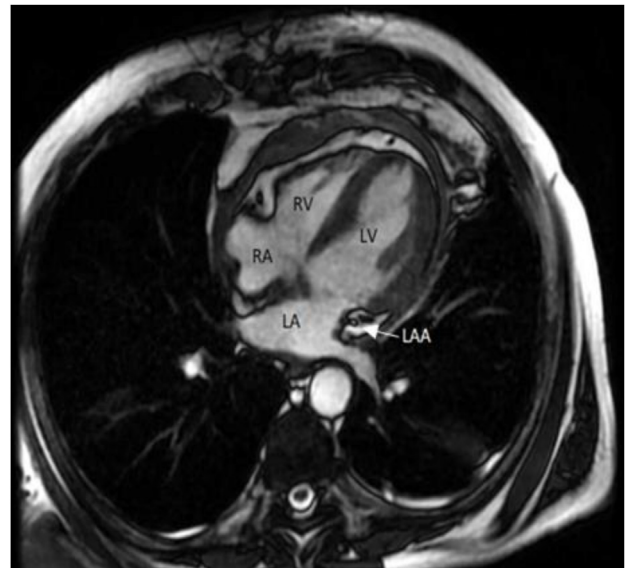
Cardiac MRI showing heterogeneous thickening of pericardium, normal LAA.
